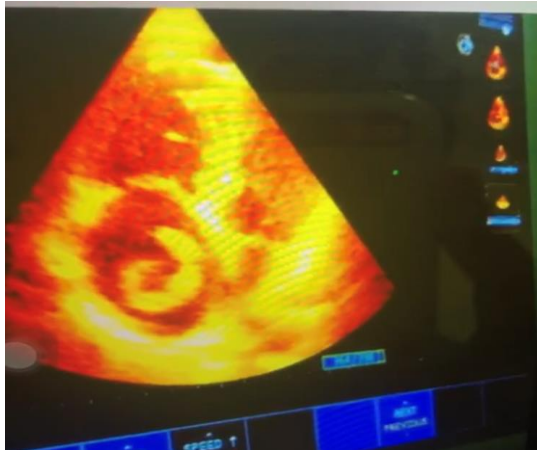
Apical four-chamber view showing a worm-like thrombus in the right atrium
